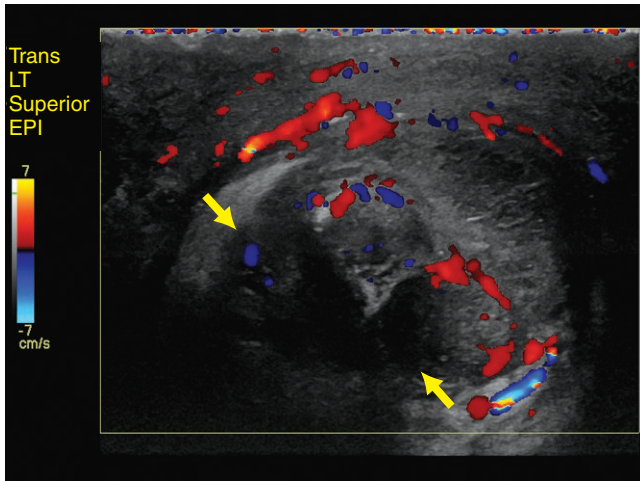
Transverse ultrasound of another patient through the region of the epididymis shows hypoechoic masses (arrows).
